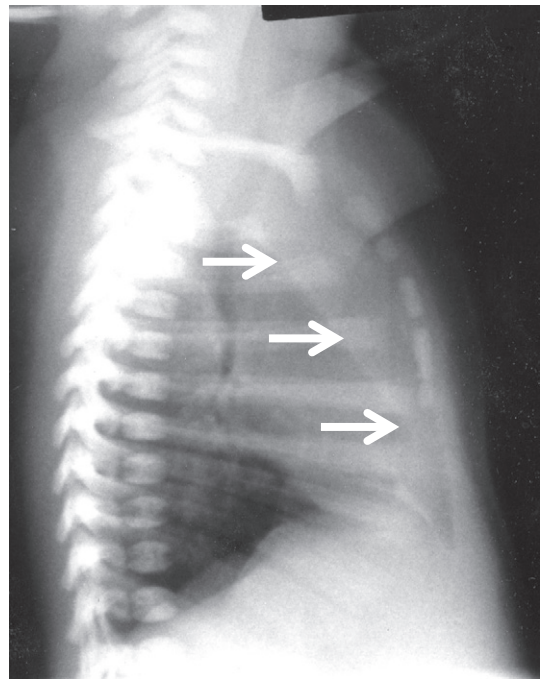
Lateral chest radiograph demonstrating the anterior dense strip running parallel to the sternum from the apex of the chest to the xiphoid process (white arrows).
